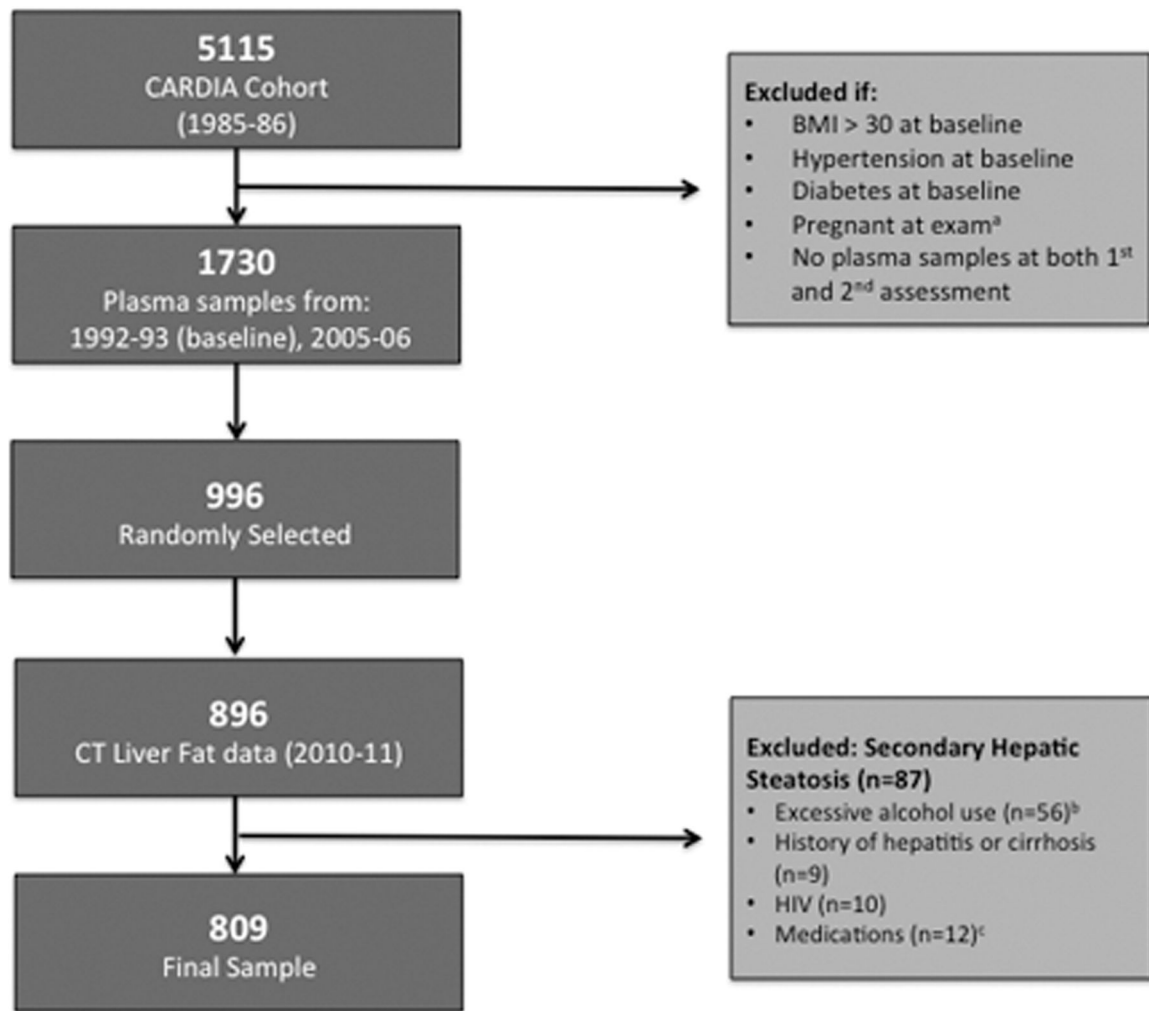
Cohort selection. ^aParticipants pregnant at any exam (1992–1993, 2005–2006, 2010–2011) were excluded. ^bExcessive alcohol use was defined as 14 drinks/wk in women and 21 drinks/wk in men. ^cMedications = corticosteroids, amiodarone, methotrexate, tamoxifen, valproic acid. BMI, body mass index; CT, computed tomography; HIV, human immunodeficiency virus
